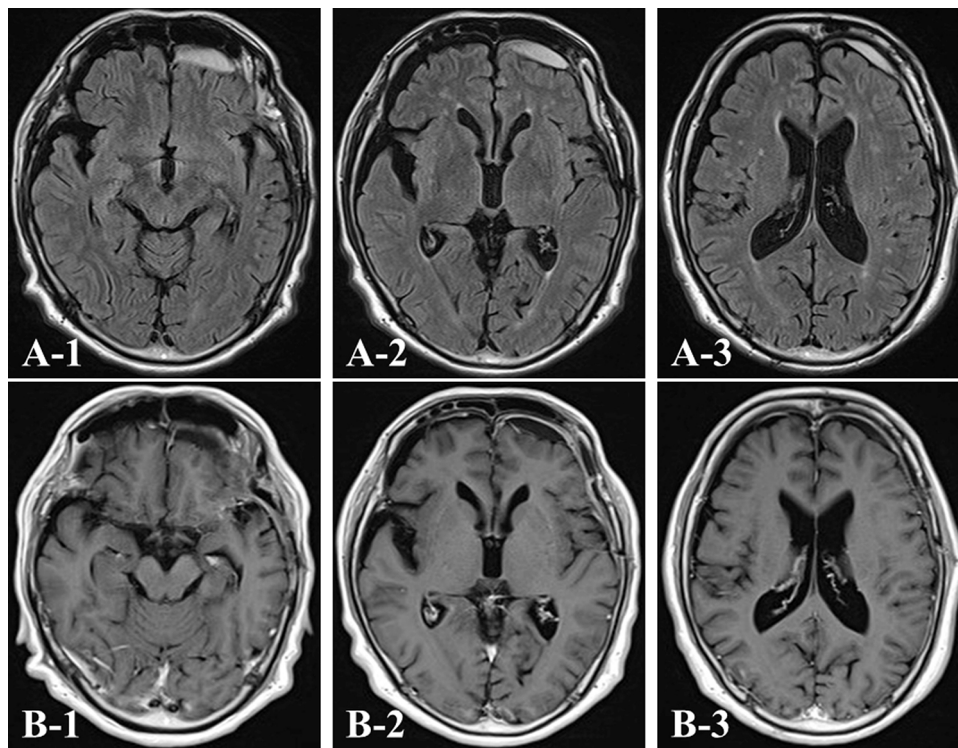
Magnetic resonance imaging (MRI) findings. Axial fluid-attenuated inversion recovery (FLAIR) (A) and gadolinium (Gd)-enhanced T1-weighted (B) MR images showing slight retention of the subdural hematoma. The hematoma is not enhanced on the administration of Gd.
